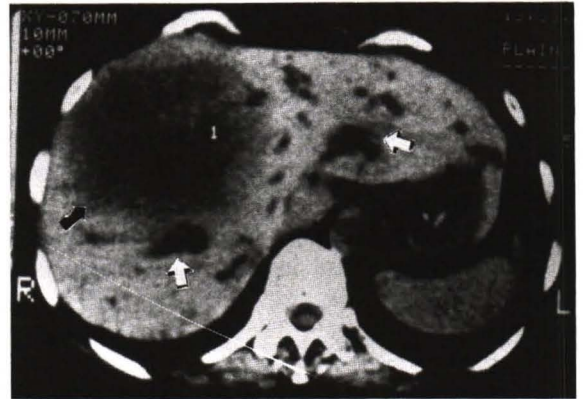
Case 3. CT scan liver revealed a huge low attenuated mass at right lobe liver (black arrow) with dilated intrahepatic duct (white arrow).
